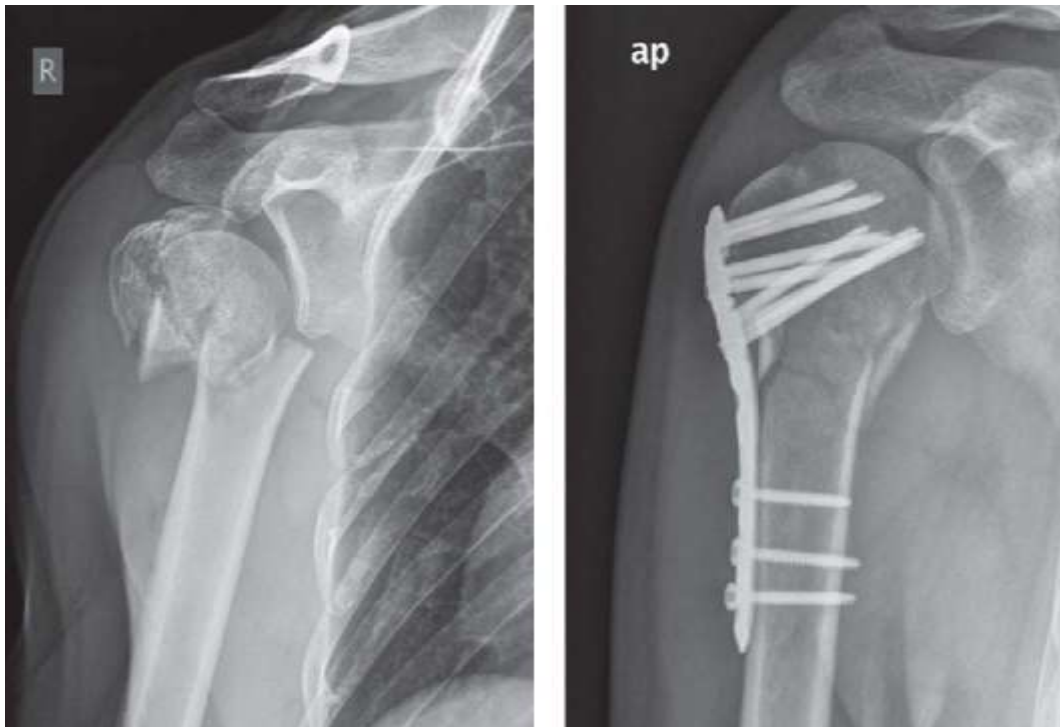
The pre- and post-operative X-ray of 73 years old male with proximal humerus fracture.
